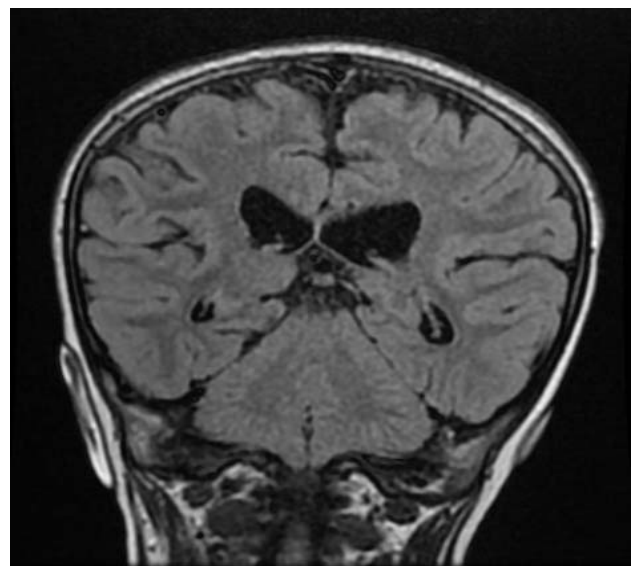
Coronal FLAIR sequence shows midline fused cerebellar hemispheres, peduncles and vermis.
